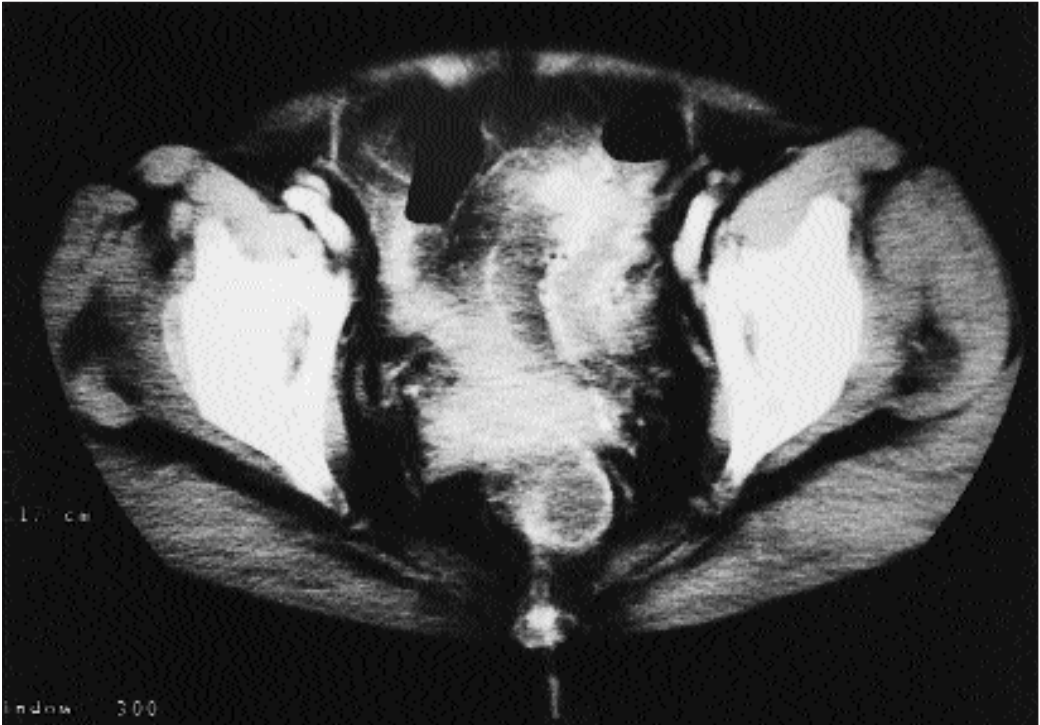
Abdominal CT showing a thick walled sigmoid surrounded by an area of paracolic inflammation and out-pouchings representing diverticuli.
